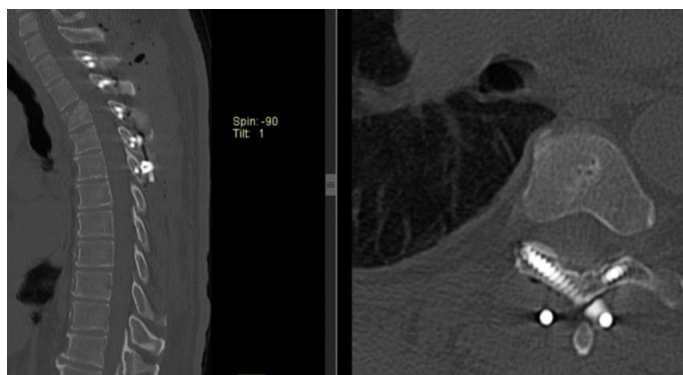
Postoperative CT scan all the screws are intralaminar, sufficient ligamentotaxis effect of the fixation
